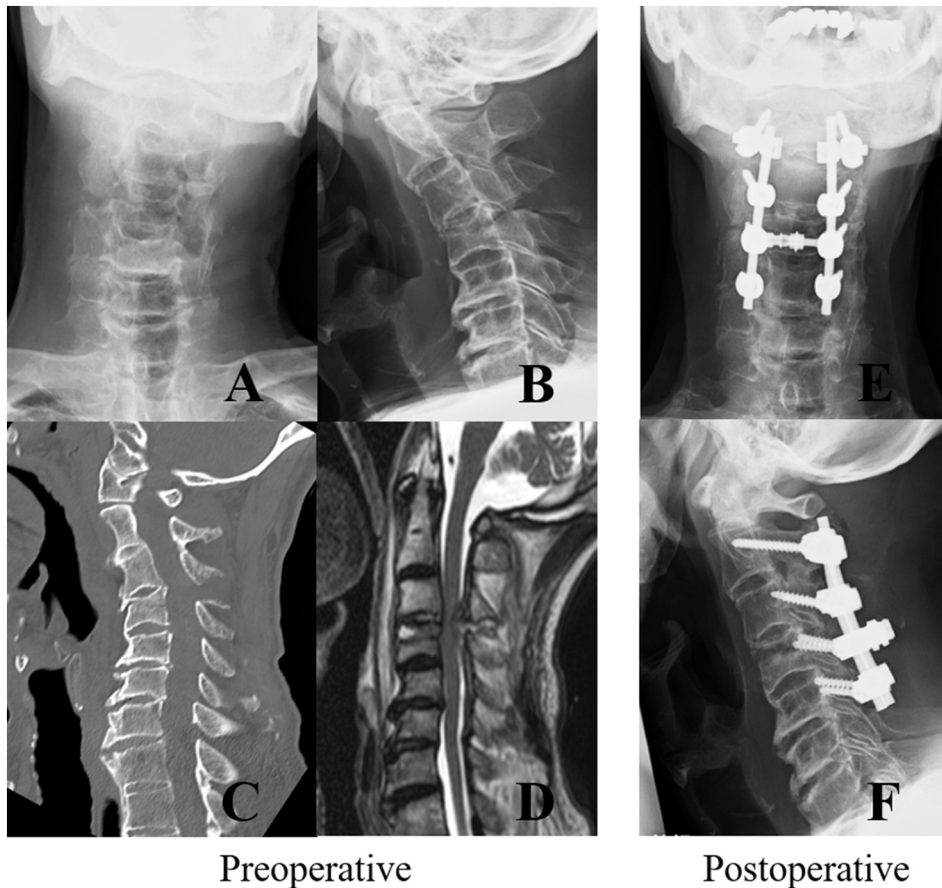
Preoperative radiographs, CT imaging and MRI imaging of the cervical spine showing the C4 fracture with diffuse idiopathic skeletal hyperostosis and spinal cord compression (A: anterior-posterior view B: lateral view C: sagittal view D: T2-Weighted sagittal view) We performed laminectomy and posterior fixation of C2–5 (E: anterior-posterior view F: lateral view).
